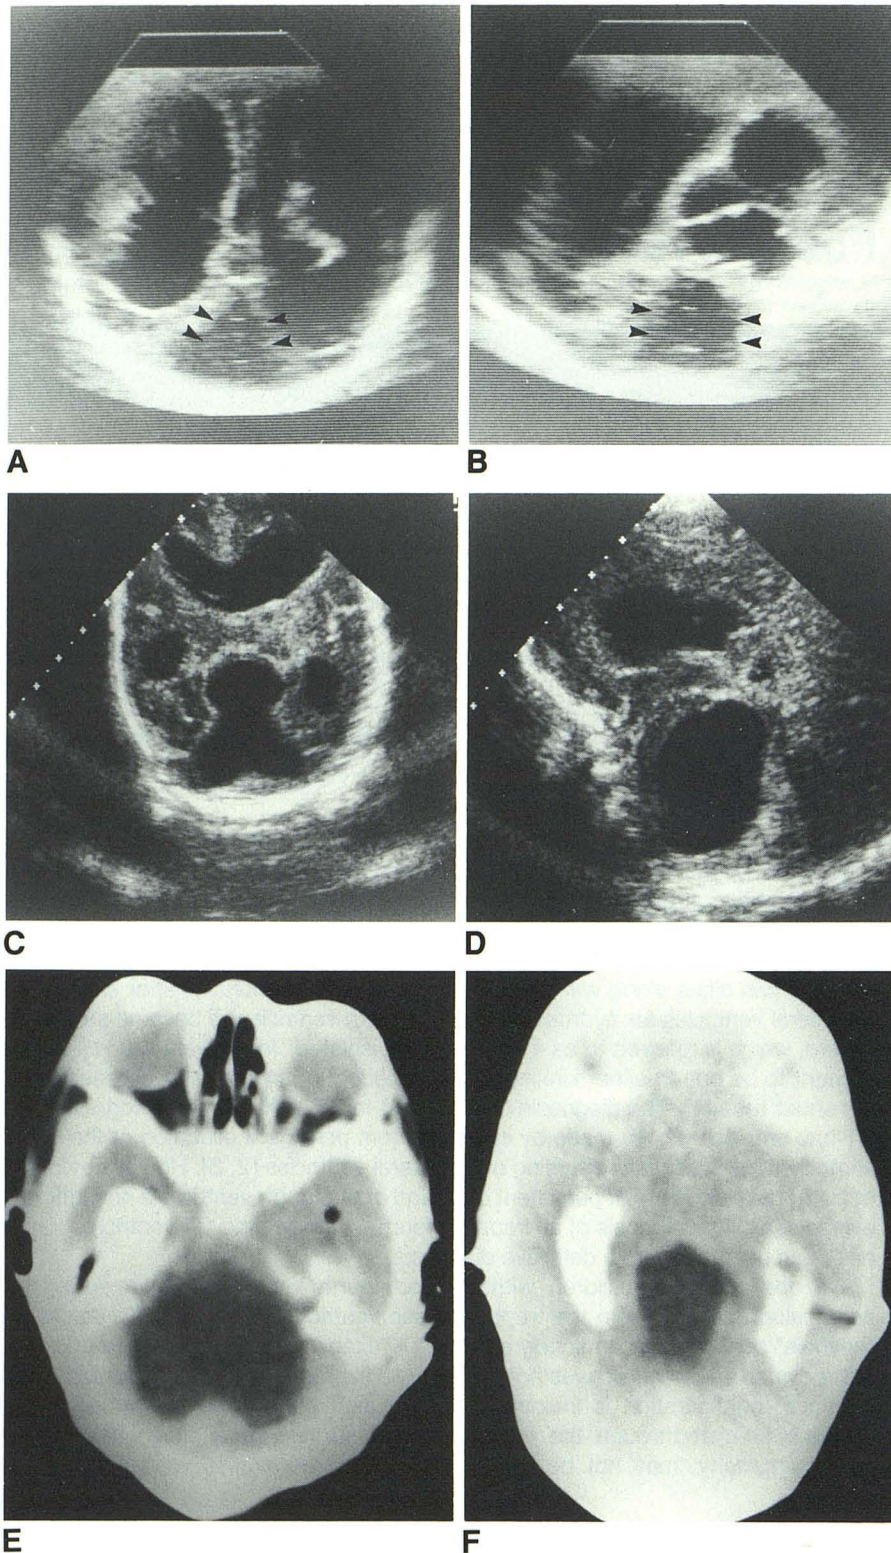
Case 1. Sonographic examination at age 27 days shows dilatation of all ventricles including fourth ventricle (arrows) in coronal (A) and sagittal (B) planes. Sonographic examination at 4 months old, 3 months after initial shunt, shows "keyhole" fourth ventricle in coronal plane (C). Herniation of fourth ventricle is not easily identified on sagittal view (D). CT contrast ventriculography shows that fourth ventricle does not communicate with other ventricles—i.e., infratentorial portion (E) and supratentorial portion (F) of fourth ventricle.
